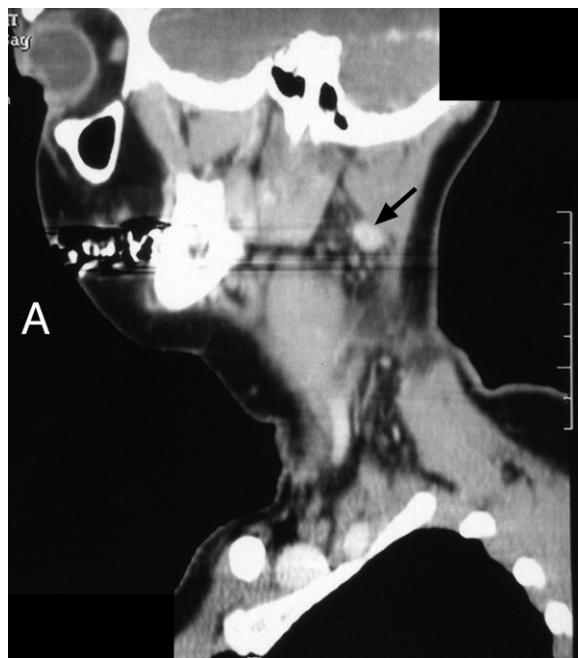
CT parasagittal image showing lymph node involvement in the upper neck on the right side (arrow).
